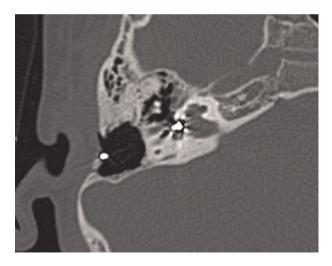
Axial, high resolution computed tomography scan showing the electrode array self-curling within the vestibule.
